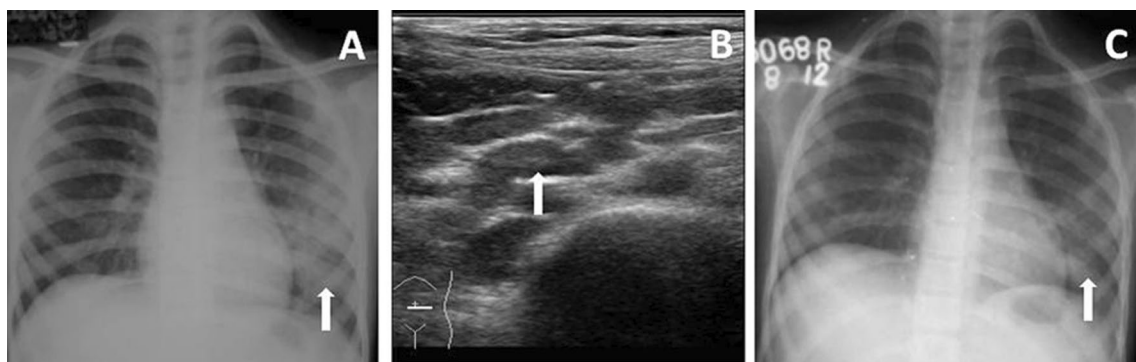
Tubercular Infection. Frontal chest radiograph in a 9-year-old HIV-positive male demonstrates confluent ill-defined nodular air-space opacities involving left lower zone (arrow, A). Ultrasound abdomen shows multiple mesenteric & retroperitoneal lymph nodes (arrow, B), some of which showed conglomeration and necrosis. His CD4 count was 256 cells/cu.mm, and Mantoux was strongly positive. Sputum could not isolate any microbe. On the basis of combined clinico-radiological findings, positive Mantoux test and CD4 count, antitubercular therapy (ATT) was started and patient improved both clinically and radiologically, showing complete resolution of the lesion (arrow, C)
